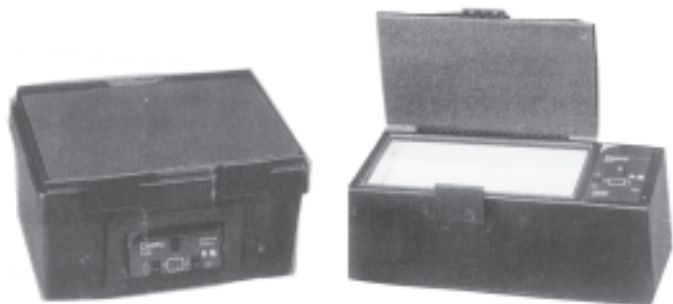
Radiographic duplicator
